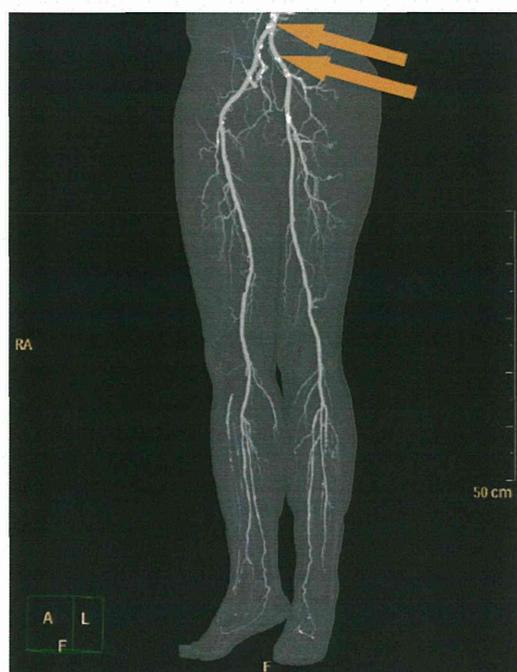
Arrows indicate multiple patchily calcified sites on the distal descending aorta and bilateral ilio-femoral arteries on the limb vascular CT.
